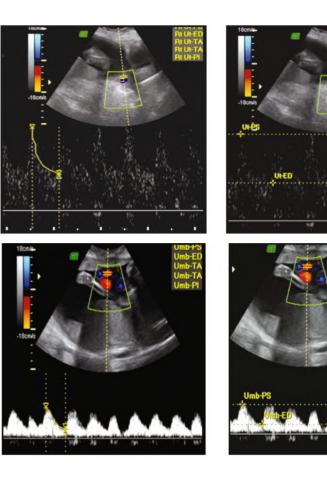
A 28-year-old female patient. With history of hypertension and on aldomet therapy during her pregnancy. She has no history of preeclampsia. She was G2P1. She gave birth by caesarean section with an average-weight baby at 25 weeks and 2 days' gestation. Assessment by Doppler of the right uterine and umbilical arteries revealed normal RIs of 0.56 and 0.67, respectively, with normal uterine artery wave and no notch.
